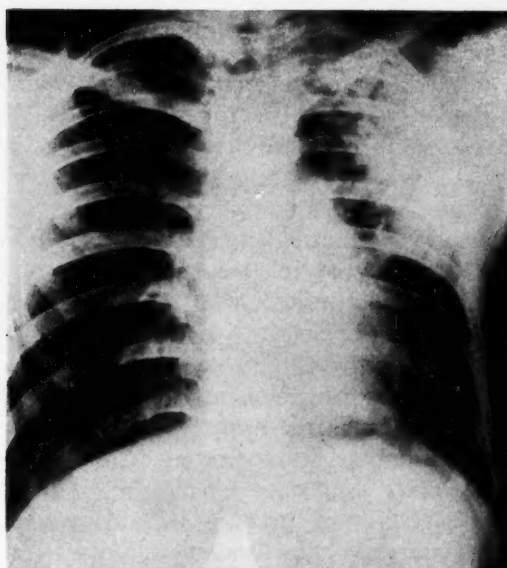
Case 1. Roentgenogram of chest; full inspiration.
